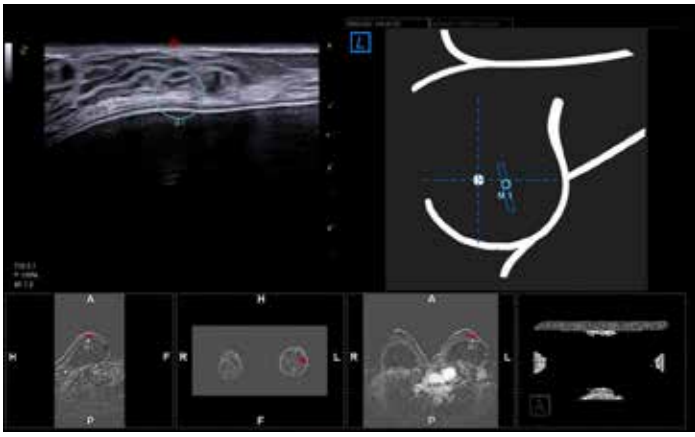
MRI-US Navigation phase: perfect match between the retroareolar lesion and the target in a dense breast with prosthesis
